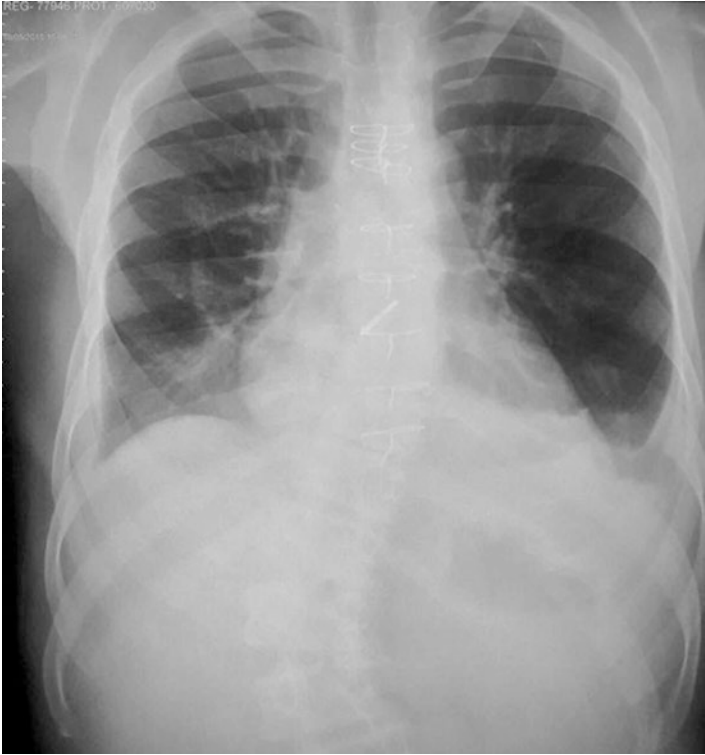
An X-ray of the patient's chest, in which it is immediately perceived as an enlarged mediastinum, a cardiac figure, and a congestive pattern of the pulmonary vessels
